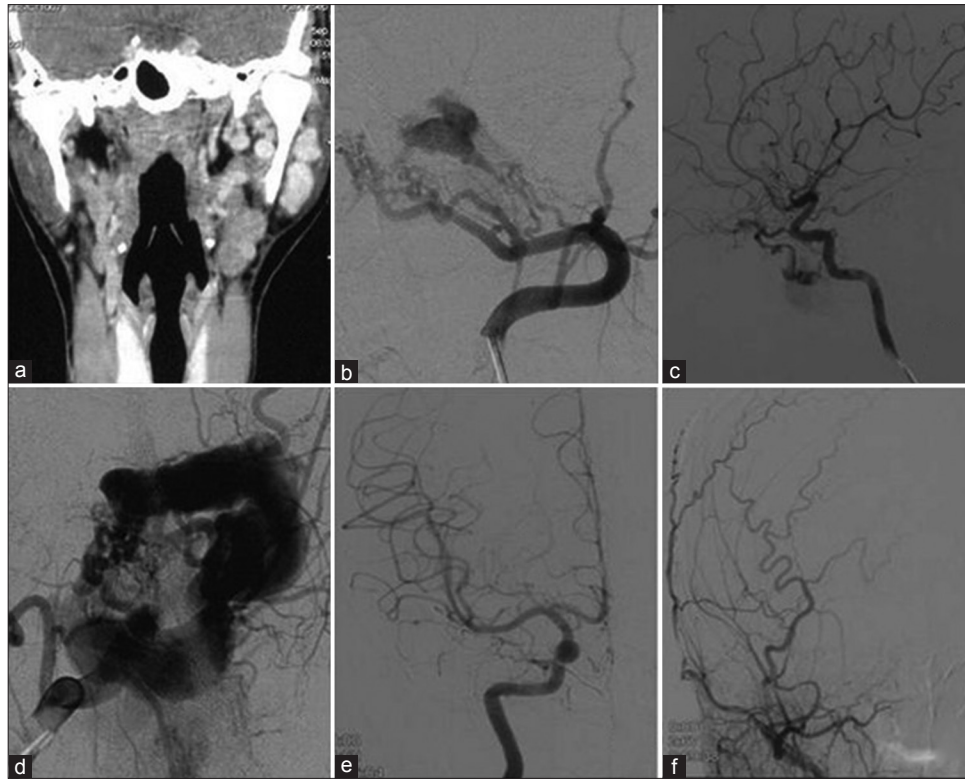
(a) Contrast-enhanced computed tomography scan detected an abnormal vascular structure involving infratemporal fossa and parotid region. (b) The left external carotid arteriogram show the arteriovenous shunt arising branches of the middle meningeal artery and internal maxillary. (c) The left internal carotid arteriogram show the arteriovenous shunt arising branches of the left ophthalmic artery, cavernous internal carotid artery. (d) The arteriovenous shunt drains via a large venous pouch to the external carotid vein. (e) The right internal carotid arteriogram. (f) The right external carotid arteriogram
